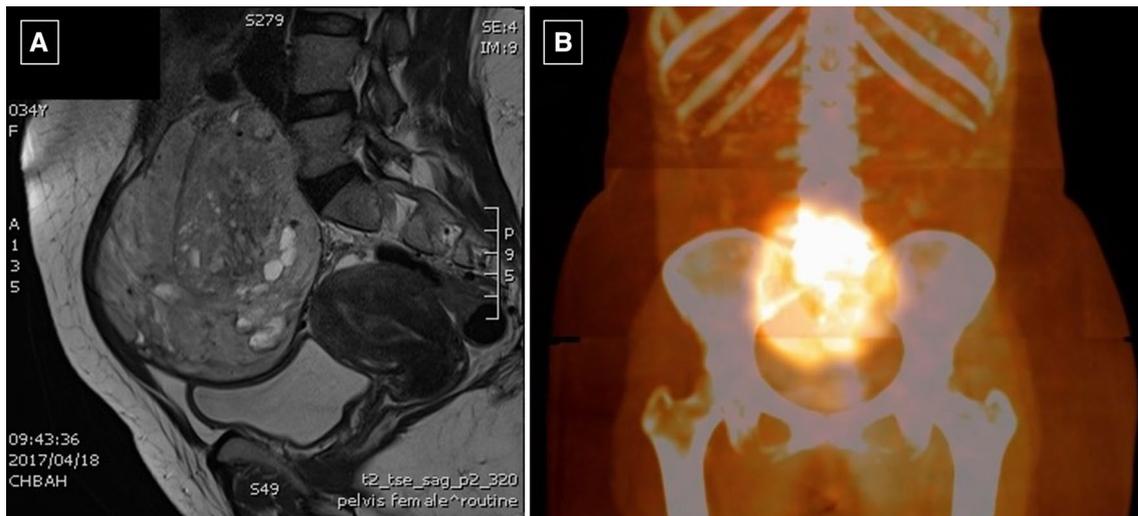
a Sagittal MRI showing a large paraganglioma arising from the organ of Zuckerkandl. b Multiplanar reformatting fusion image demonstrates diffuse uptake of iodine-123 meta-iodobenzylguanine within the tumour
